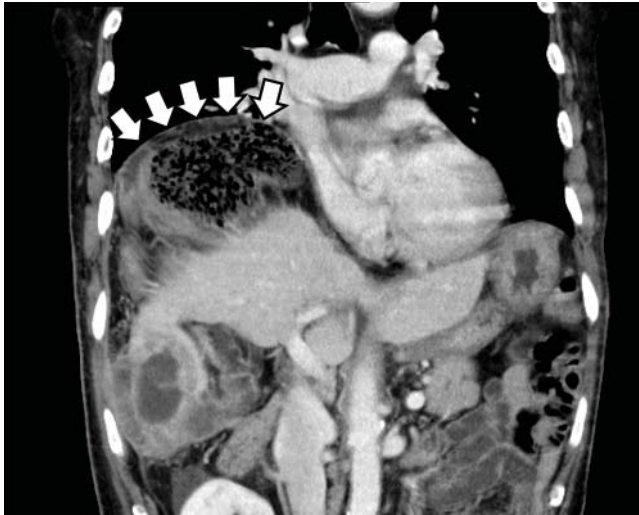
The Chilaiditi sign on computed tomography, with volvulus of the cecum between the diaphragm and liver and a closed-loop obstruction (arrows).
